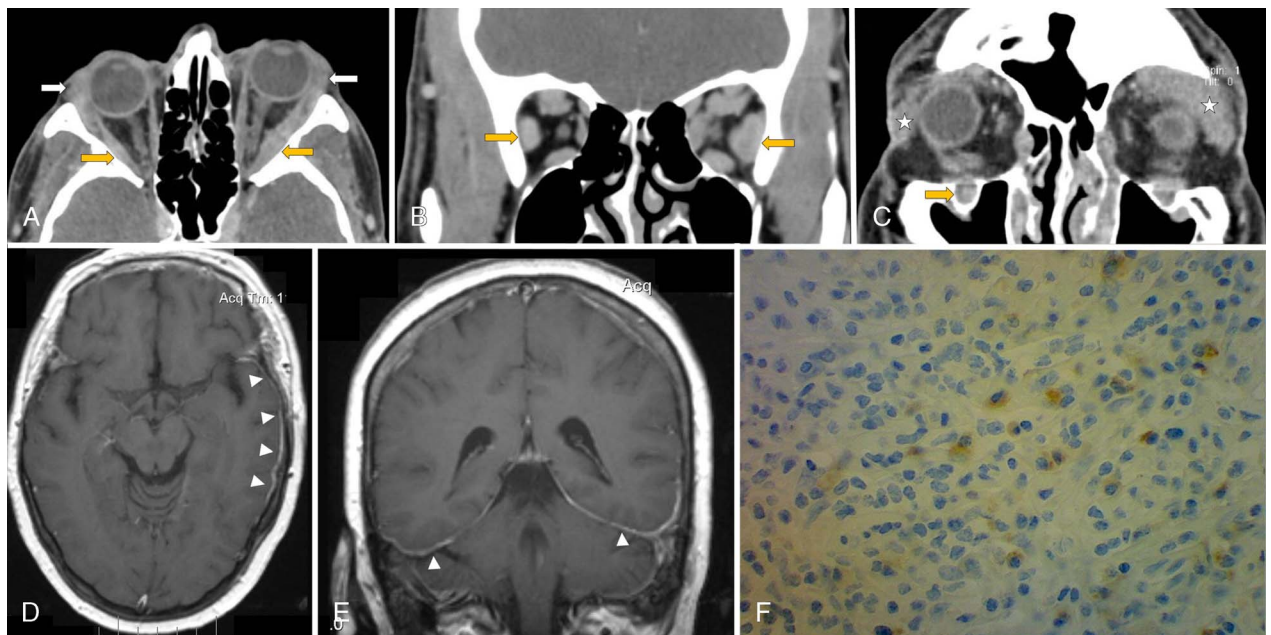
A, Axial CT showing bilateral lacrimal gland (white arrows) and lateral rectus enlargement (yellow arrows), more evident in the left eye causing proptosis in a 46-year-old man. B, Coronal CT image from the same patient shows superior, lateral, and inferior rectus enlargement bilaterally; the lateral rectus is the most enlarged among the rectus muscles (yellow arrow). C, Coronal CT image from 48-year-old patient with infraorbital nerve enlargement (yellow arrow) and bilateral lacrimal gland enlargement (stars). Axial (A) and coronal (B) contrast-enhanced MR imaging of the brain showing hypertrophic pachymeningitis in a 45-year-old woman hospitalized due to quadriplegia, visual alterations, and headache; (C) dural biopsy revealed >30 IgG4+ plasma cell/HPF with an IgG4/IgG ratio >40 (×400). Color online-figure is available at <http://www.jclinrheum.com>.
